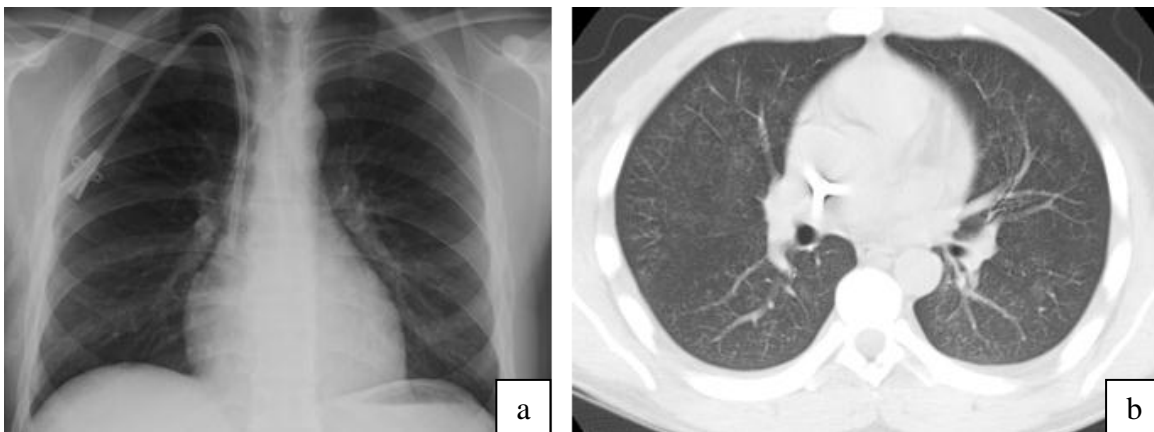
Follow-up chest x-ray (a) and non-contrast chest CT images (b) showed bilateral air space opacities largely resolved following hemodialysis.
